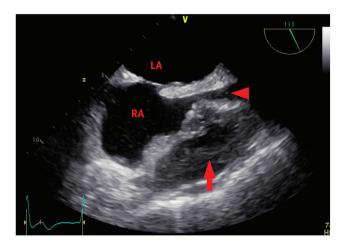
Transesophageal ultrasound imaging of the bicaval view (115° probe rotation). This image demonstrates a compression of the right atrium (RA) and the superior vena cava (arrowhead) by a 'hidden' posterior pericardial clot (arrow).
